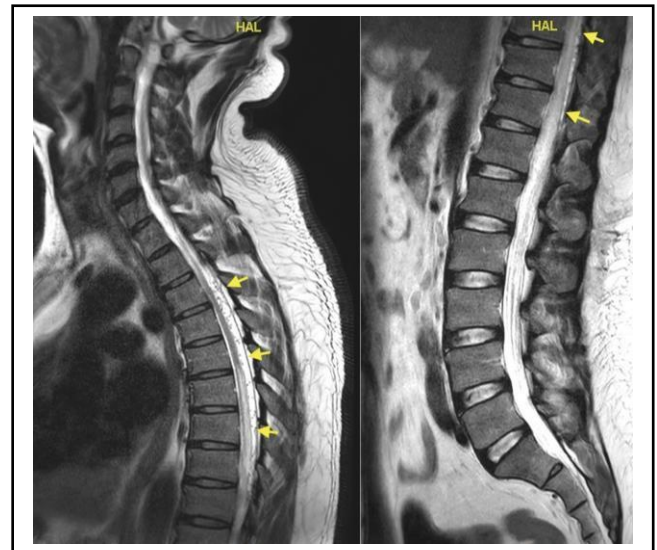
MRI T2 showing intradural extramedullary serpiginous flow voids at the dorsal aspect from T3 to T11 vertebral levels (Yellow Arrow) with mild enhancement seen.
